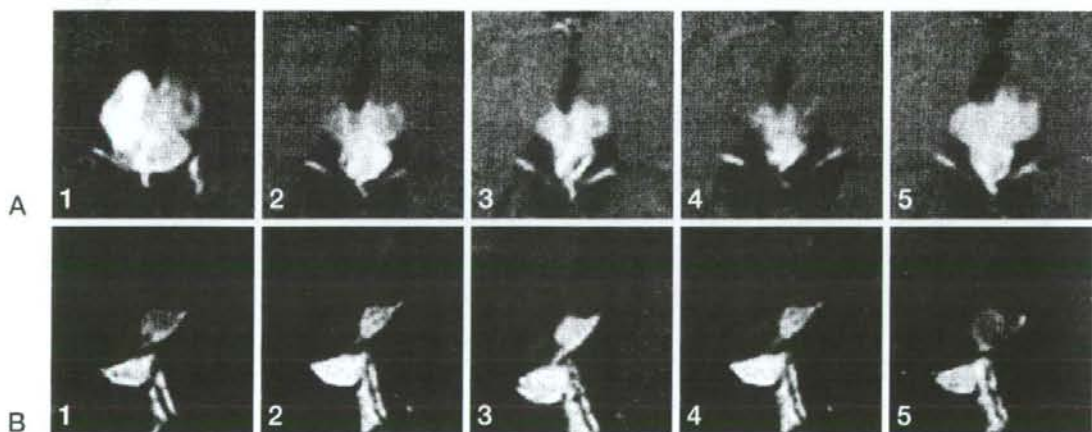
Serial gadolinium-enhanced MR images obtained on June 13 (1), June 26 (2), July 3 (3), July 14 (4), and August 1 (5). The pineal (A: axial) and suprasellar tumors (B: sagittal) continued to decrease in size until July 14 and subsequently began to enlarge.
